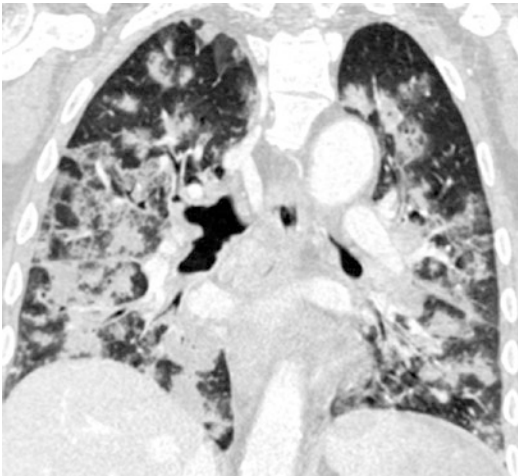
CT coronal image of the chest demonstrates multiple patchy ground-glass opacities of the lungs
